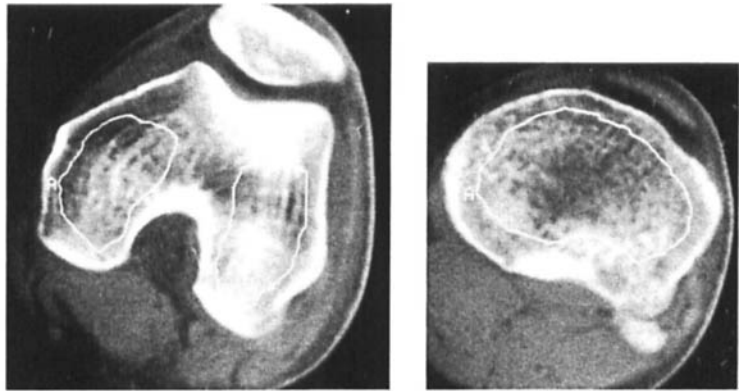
CT scans of femoral and tibial condyles. Trabecular bone density was measured in areas indicated by lines.
